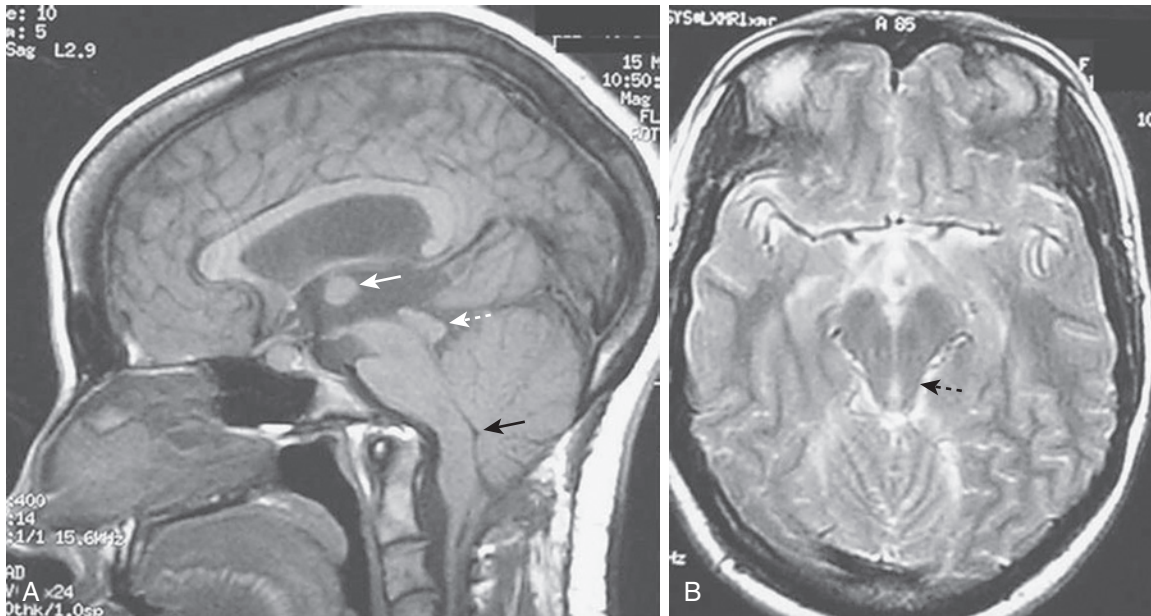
A, Sagittal T1-weighted magnetic resonance imaging (MRI) of an adult patient with Arnold-Chiari type II deformity. The posterior fossa is small with a widened foramen magnum. Inferior displacement of the cerebellum and medulla with elongation of the pons and fourth ventricle (*black arrow*) is evident. The brainstem is kinked as it passes over the back of the odontoid. An enlarged massa with intermedia (*white arrow*) and beaking of the tectum (*broken white arrow*) are visible. B, Axial T2-weighted MRI shows the small posterior fossa with beaking of the tectum (*broken black arrow*). (From Waldman SD, Campbell RSD. *Imaging of pain*. Philadelphia: Saunders; 2011:30.)
